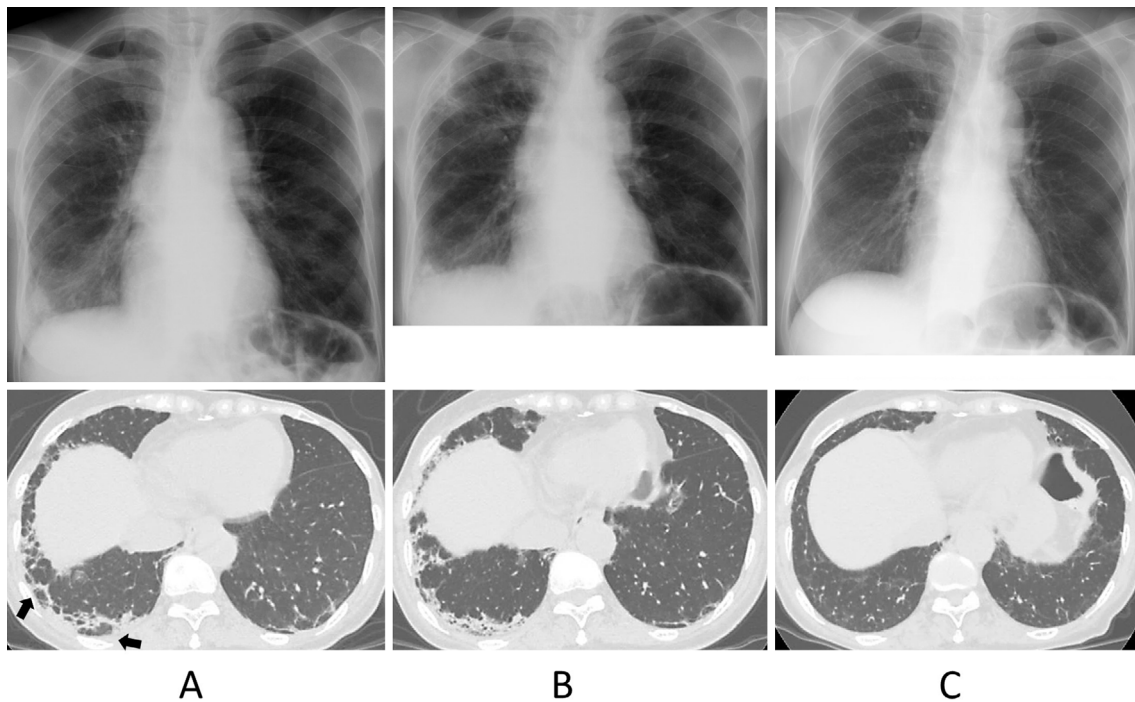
Chest radiography and high-resolution CT findings in Case 8. (A) Chest radiography on admission demonstrated consolidation mainly in the right lower lung field. Chest CT showed peribular opacity in the subpleural region (arrows). (B) As the disease progressed, the peribular opacity thickened, forming consolidation with apparent lung volume loss in 13 days. (C) In the recovery phase, the consolidation decreased, and the loss of lung volume recovered 31 months after the first visit.
